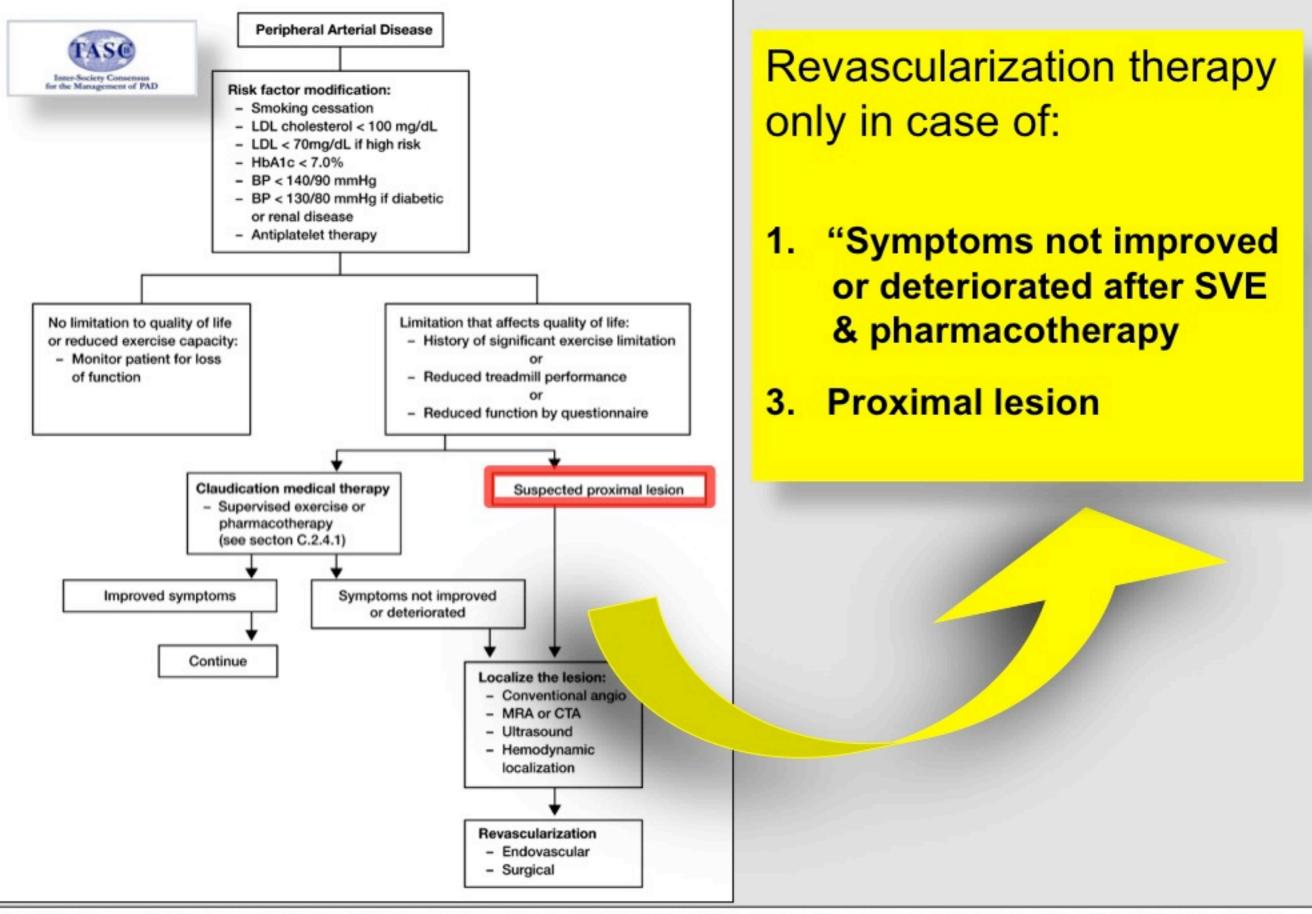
Overall treatment strategy for peripheral arterial disease. BP – blood pressure; HbA1c – hemoglobin A1c; LDL – low density lipoprotein; MRA – magnetic resonance angiography; CTA – computed tomographic angiography. Reproduced with permission from Hiatt WR. N Engl J Med 2001;344:1608–1621.
